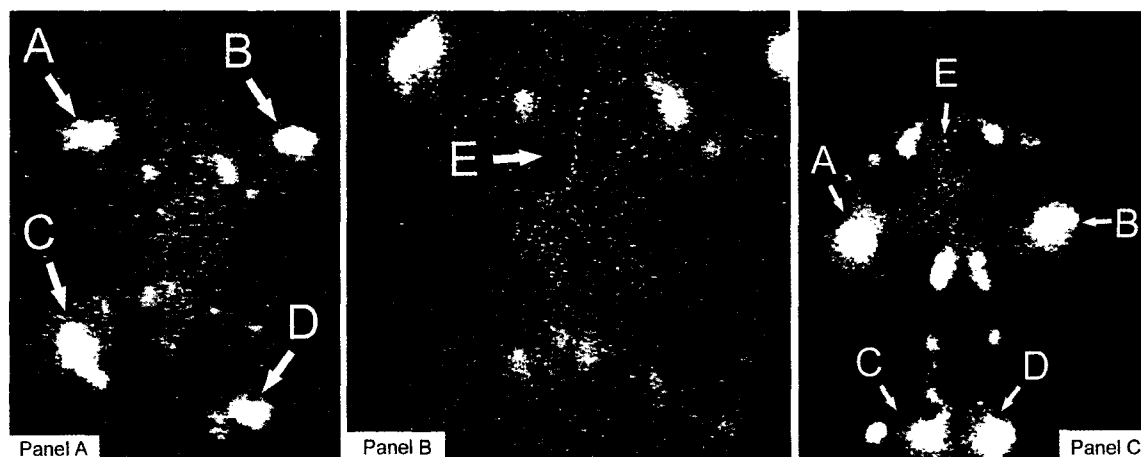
Panels A and B: case 1. Panel C: case 2. Arrows A, B, C, and D indicate the right hand, left hand, right foot, and left foot, respectively. Arrow E indicates the thoracic duct. Lymphangioscintigraphic images were obtained following intradermal injection of Tc-99m microcolloidal sulfide (Lymphoscint, Nanocool, Solco Basel, Ltd, Basel Switzerland). Images were obtained approximately 5 minutes after completion of the simultaneous injections in the 4 limbs. Case 1. Panels A and B. Tracer accumulation is evident in the distal portion of both lower limbs, along with tracer accumulation (presence) within the thoracic duct (arrow E), indicating radiocolloid transport in the superficial dermal lymphatics and persistence in the thoracic duct. Case 2. Panel C. Rapid transport of the tracer was evident in the right lower limb, consistent with lymphatic hyperplasia. Initial dermal backflow is seen in the distal portion of the hand and foot reflecting radiocolloid transport in the superficial channels of the dermis. Tracer accumulation in the thoracic duct is also seen (arrow E). Visual findings of lymphoscintigraphy are evaluated by determination of a numeric index of transport kinetics (16). Case 1. The transport index in both upper limbs and the lower left limb was normal (TI= 2), while the TI of the lower right limb was pathological (right limb: TI= 45). Case 2. The TI of four limbs was normal (TI= 2). TI was calculated from the formula: $TI = K + D + 0.04T + N + V$, where K is lymphatic transport kinetics (no delay, low grade delay, extreme delay, lack of transport are 0, 3, 5, and 9, respectively), D is the distribution pattern of the tracer (normal, partial diffuse, diffuse, transport stop are 0, 3, 5, and 9, respectively), T is the time in minutes of tracer appearance in the lymph nodes (no appearance is 9), V is the ratio between the visualization of lymph vessels and graft (nodes and vessels, respectively, clearly demonstrated, faint visualization, hardly recognizable, no visualization are 0, 3, 5, and 9, respectively). Each parameter ranges from 0 to 9, so total score ranges from 0 (normal) to 45 (pathological) (16).
